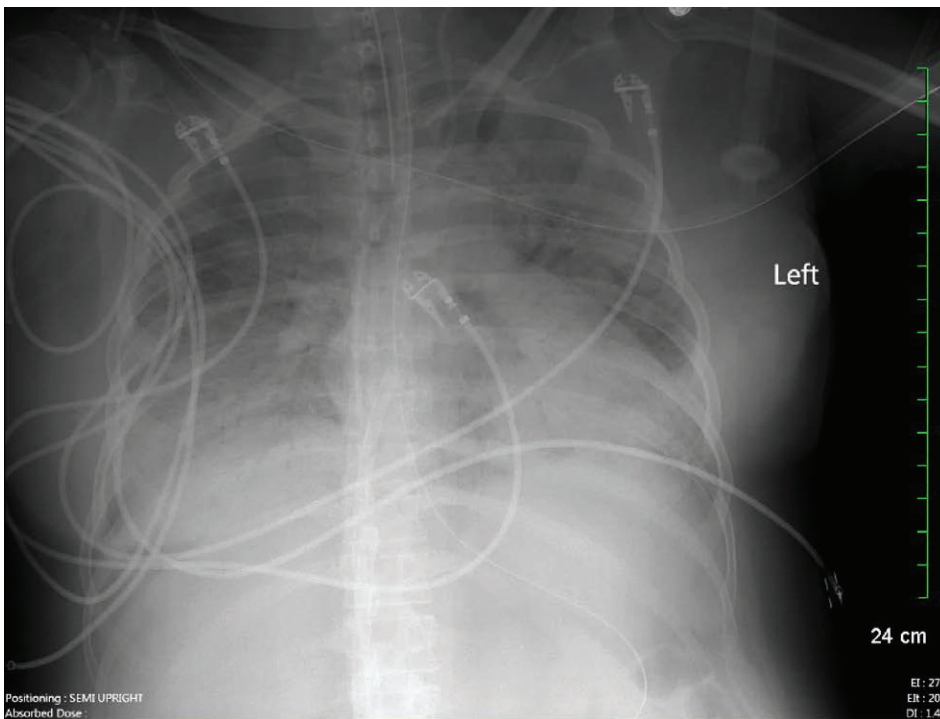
Chest x-ray showing diffuse pulmonary opacities consistent with SARS-CoV-2 infection.
